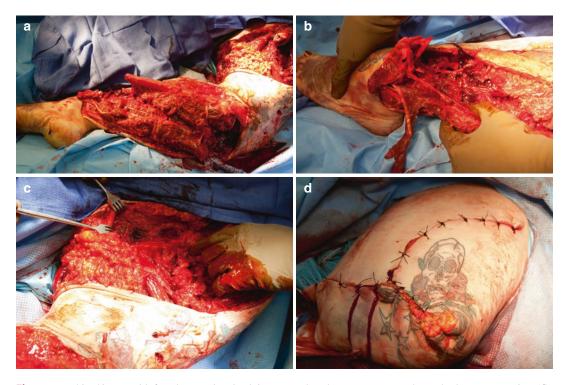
This 40-year-old female was involved in a severe motorcycle crash. In Figures (a-c) profound softtissue and osseous damage was sustained. Emergency department evaluation demonstrated the foot be avascular. The patient underwent emergent operative intervention and underwent an acute above-the-knee amputation (d). She returned to the operating suite several times over the ensuing days for further debridement and, ultimately, a disarticulation of the hip joint. Radiographs for this patient are shown in Fig. 22.7
